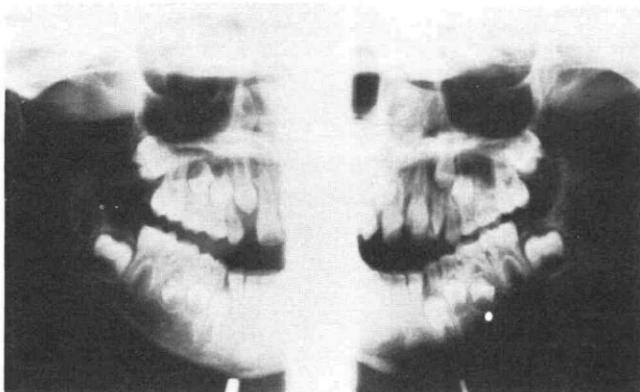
Panoramic radiograph at 7 years, 11 months.
